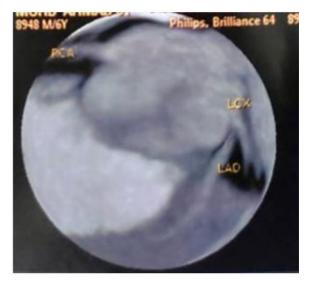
Coronary CT Angiography reveals normal coronary artery origins.
